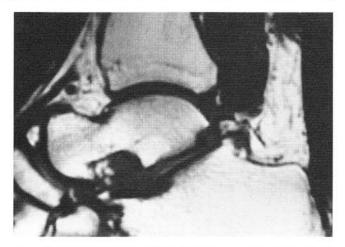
MRI demonstrating fluid collection associated with the flexor hallucis longus tendon just above the os trigonum.
